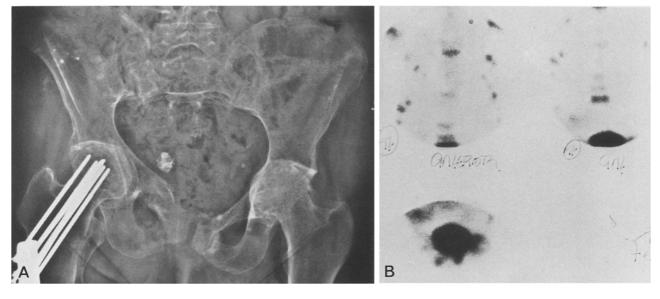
False-positive scan caused by multiple insufficiency fractures in woman with rheumatoid arthritis. A Radiograph reveals fractures of both pubic bones and right femoral neck, and uniform narrowing of hip joints and protrusio acetabuli secondary to rheumatoid arthritis. B Scan reveals increased activity at sites of numerous fractures in spine, ribs, and pelvis. Fractures of pubic bones are partially obscured by radioisotope-filled urinary bladder
